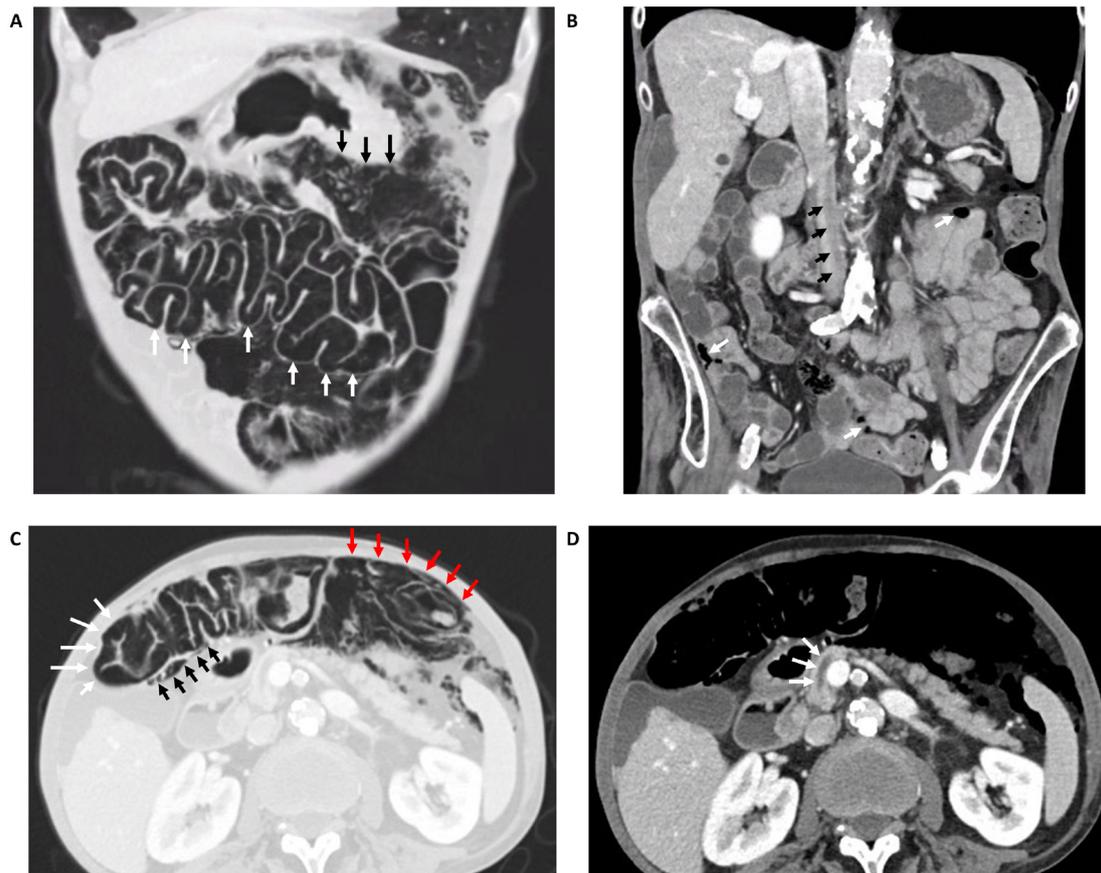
Contrast-enhanced computed tomography. (A) Lung windowed coronal section showing intramural air in the colon transversum (white arrows) and associated air in the mesenteric root and pneumoperitoneum (black arrows). (B) Soft tissue windowed coronal section showing air-filled intestinal cysts (white arrows) and air in mesenteric vein (black arrows). (C) Lung windowed axial section showing intramural air in the colon transversum (white arrows) and associated air in the mesenteric root (black arrows) and pneumoperitoneum (red arrows). (D) Soft tissue windowed axial section showing air in the mesenteric vein (white arrows).
